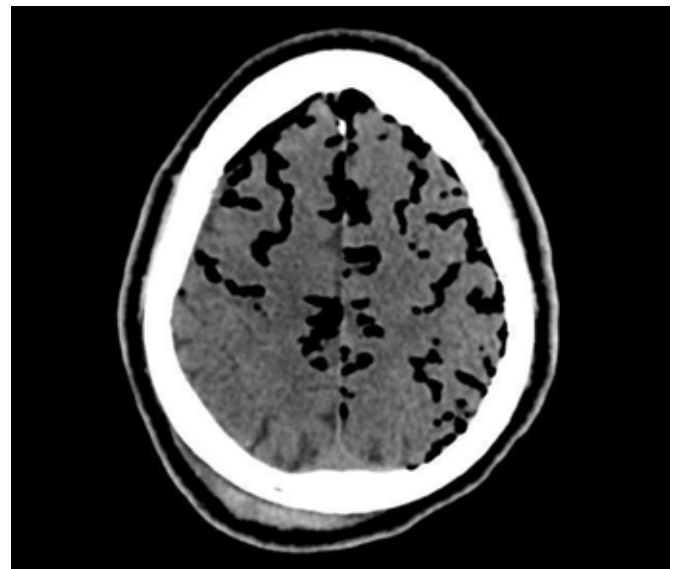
In this CT scan there are multiple small foci of air within the subarachnoid space which is called air bubble sign that also result from increased tension of air in the subdural space.
